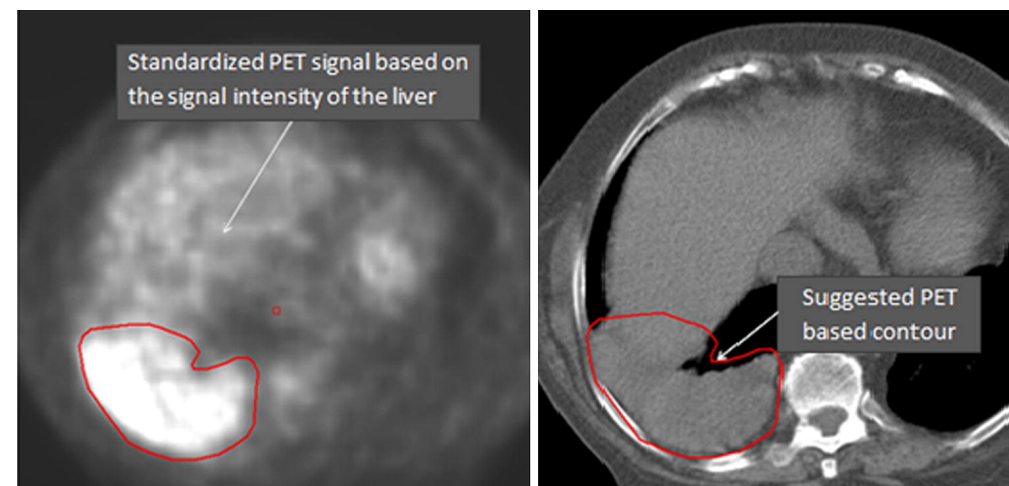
Example of a standardized signal intensity based on the signal brightness of the liver. The PET signal is very intense in the right lower lobe. When the tumor is contiguous with a non-tumor structure that has a similar density and where no tumor boundary can be distinguished on CT (e.g., when the tumor is adjacent to the liver), the reGTV should be defined by the PET FDG avid areas.
